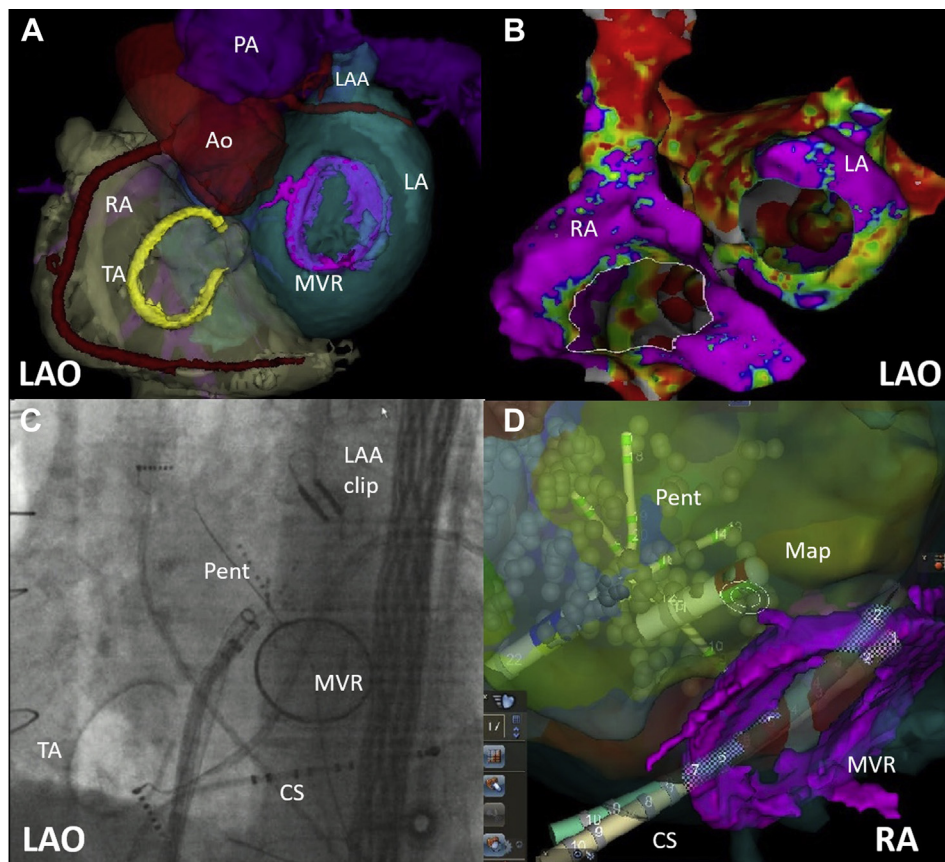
A: Three-dimensional (3D) reconstruction of a computed tomographic (CT) scan displayed in left anterior oblique (LAO) projection. The rings of the tricuspid annuloplasty (TA) and the mechanical mitral valve (MVR) are shown as well, to facilitate orientation for the operator. Note the remnant of the left atrial appendage (LAA), which is present despite surgical LAA clipping. B: Voltage amplitude map of the right (RA) and left atrium (LA). Note the scar area in the anterior wall of the LA corresponding to Waterston's access during surgery. C: Fluoroscopic image in LAO demonstrating double transeptal access and the multipolar PentaRay (Biosense Webster, Diamond Bar, CA) catheter (Pent) in the LA. D: 3D electroanatomical mapping of anterior superior aspect of the mitral valve in right anterior oblique (RAO) projection. Note that the Pent catheter has only 4 arms instead of the regular 5. Ao = aorta; CS = coronary sinus catheter; Map = mapping catheter; PA = pulmonary artery.
